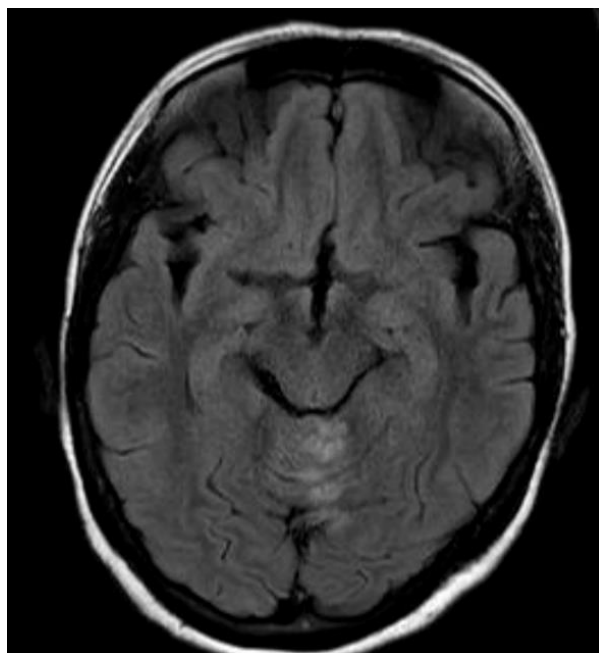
Axial brain magnetic resonance imaging in FLAIR sequence after one month of treatment shows the regression of the lesions. Bulbo-medullary lesions have resolved. Cerebellar junction lesions have smaller sizes and more conspicuous borders.
